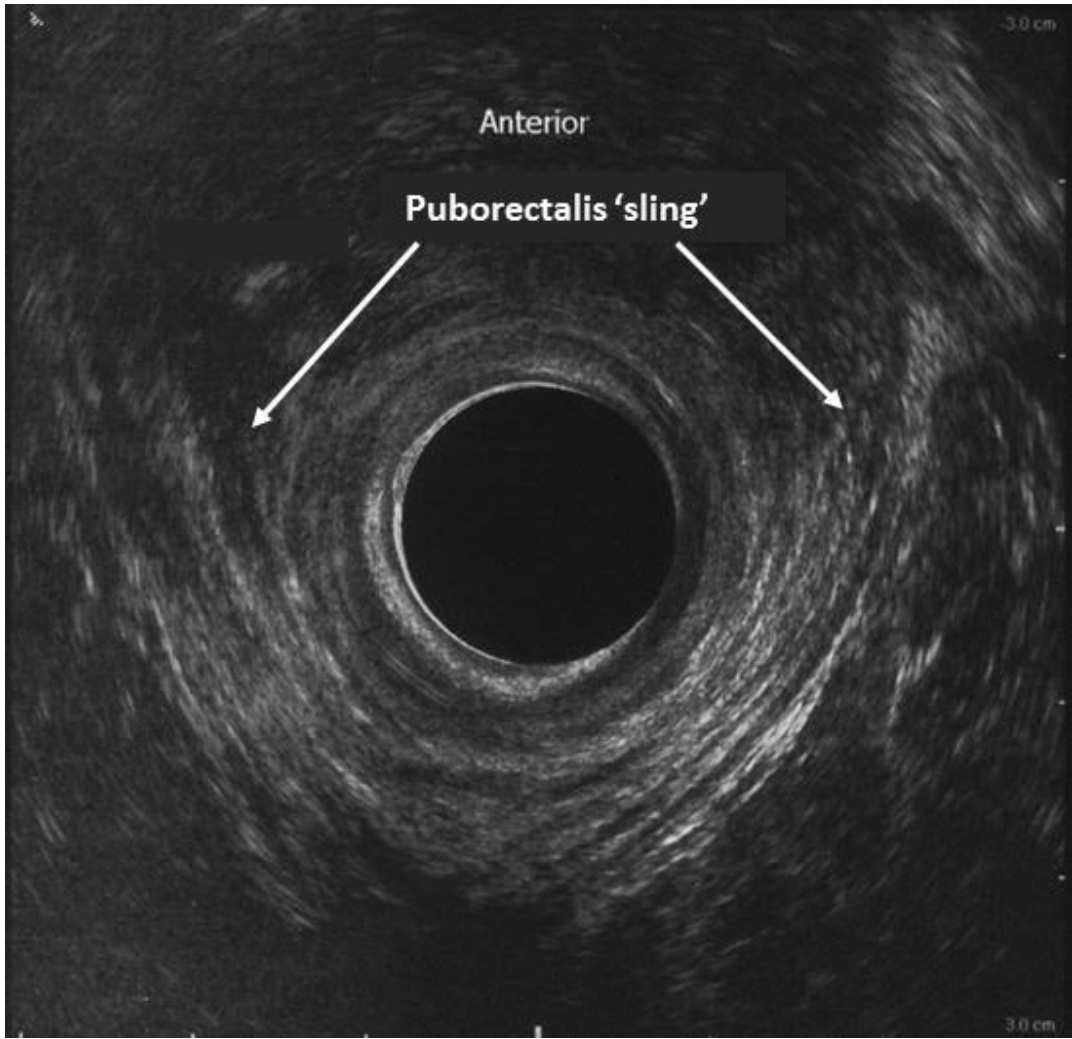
Normal ultrasound image of the deep level of the anal canal.
